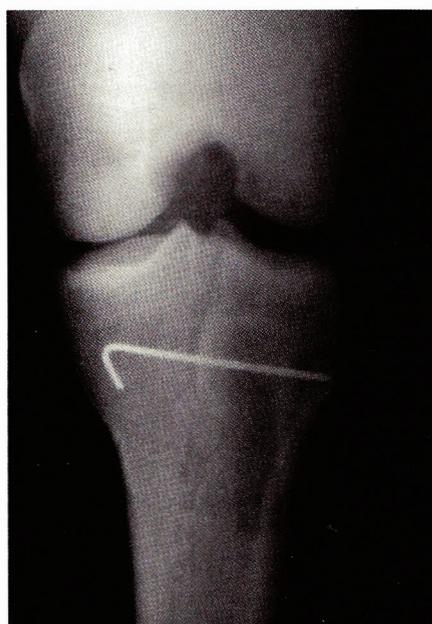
Check radiograph following ACL reconstruction.
